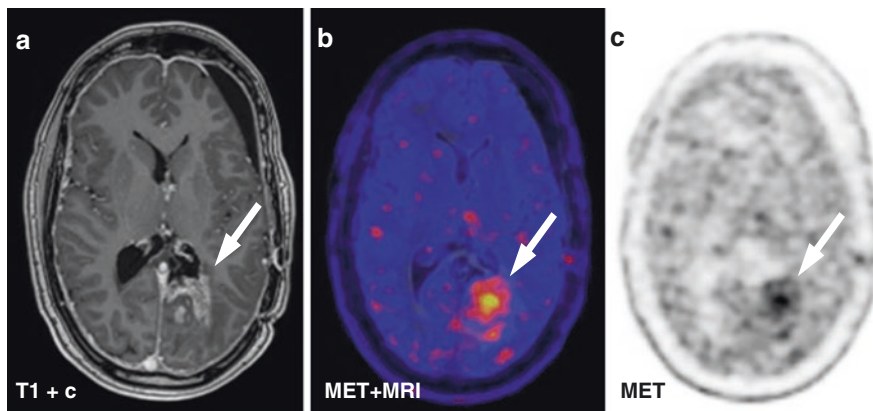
Example of MET PET follow-up in a patient with an anaplastic astrocytoma. Case of a 49-year-old patient with an anaplastic astrocytoma (WHO grade III) after treatment with surgical resection followed by radiotherapy and temozolomide chemotherapy. One year after surgery, follow-up gadolinium-enhanced MRI (a) showed new contrast enhancement (white arrow). The differentiation between tumor progression and radionecrosis could not be made, and MET PET was performed (b, c). MET PET (c) demonstrated high tracer uptake (white arrow) suggestive of tumor progression. Co-registration of MET PET images with MRI (b) shows good agreement of the contrast-enhancing lesion and increased tracer uptake
